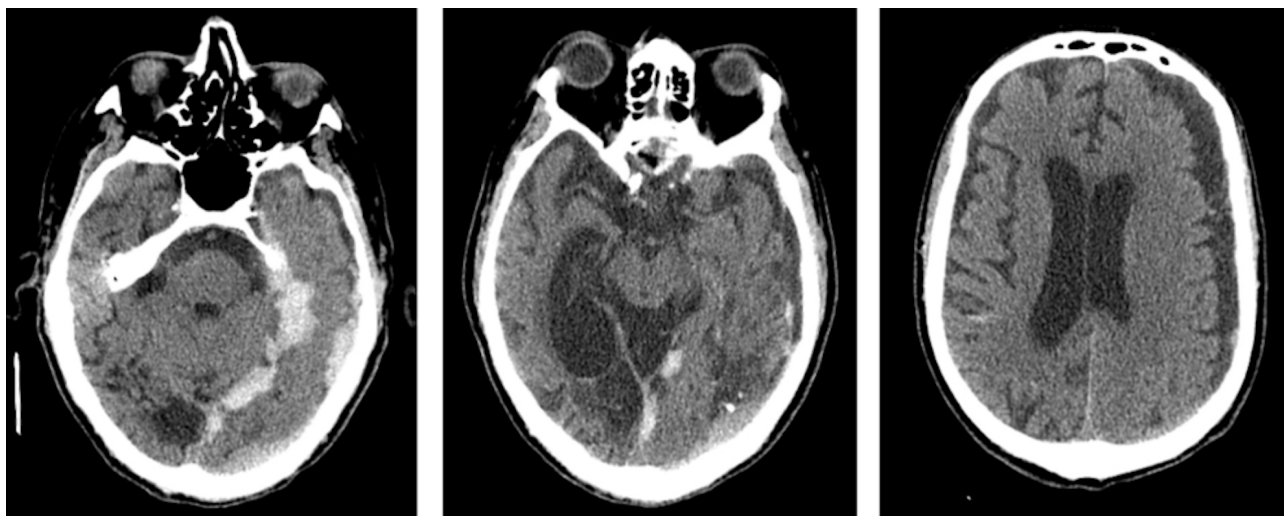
CT scan of the head. CT scan of head showing an acute left temporo-parieto-occipital subdural hematoma that shapes the regional parenchyma, with incipient midline shift to the right; an subarachnoid blood dispersed through the grooves of the hemispheres, settling in the right occipital horn; and multiple clastic lesions.
